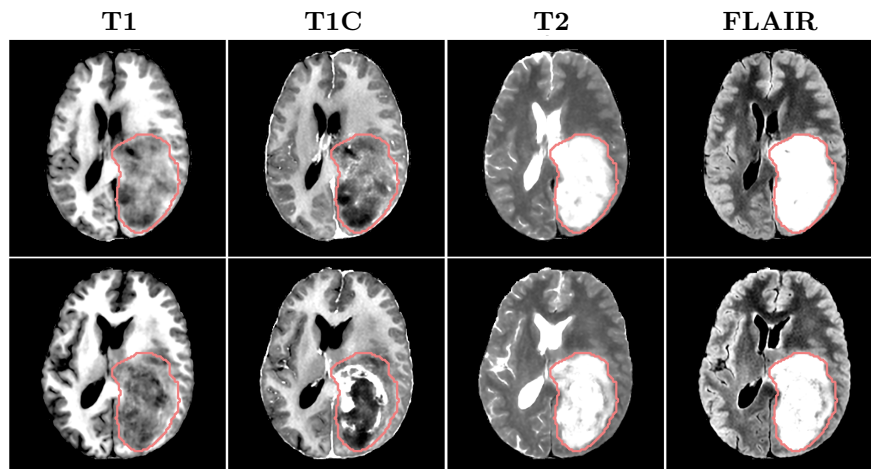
Multi-contrast MRI samples generated by the LDM using the same tumor mask (red contour) and the IDH mutation status. First row: IDH mutated example. Second row: IDH wild-type example.
